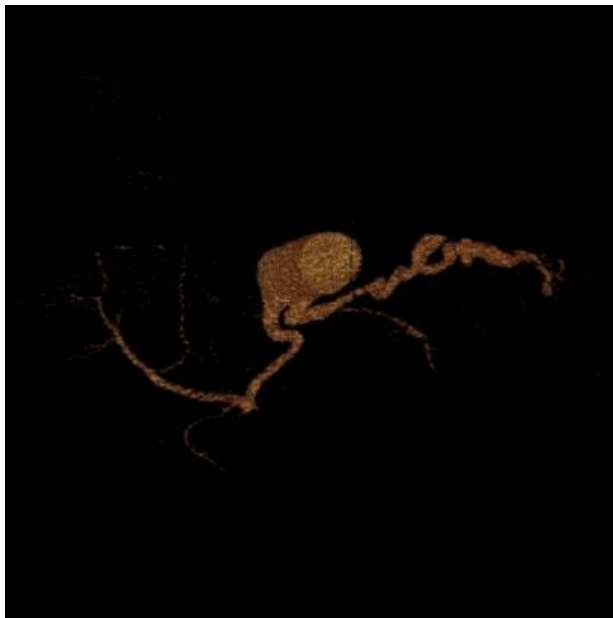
Angio-CT scan reconstruction showing the separate origins of the splenic and common hepatic arteries from the aorta (anatomical variation); the splenic artery pseudoaneurysm described by the CT scan on admittance is no longer visible.
